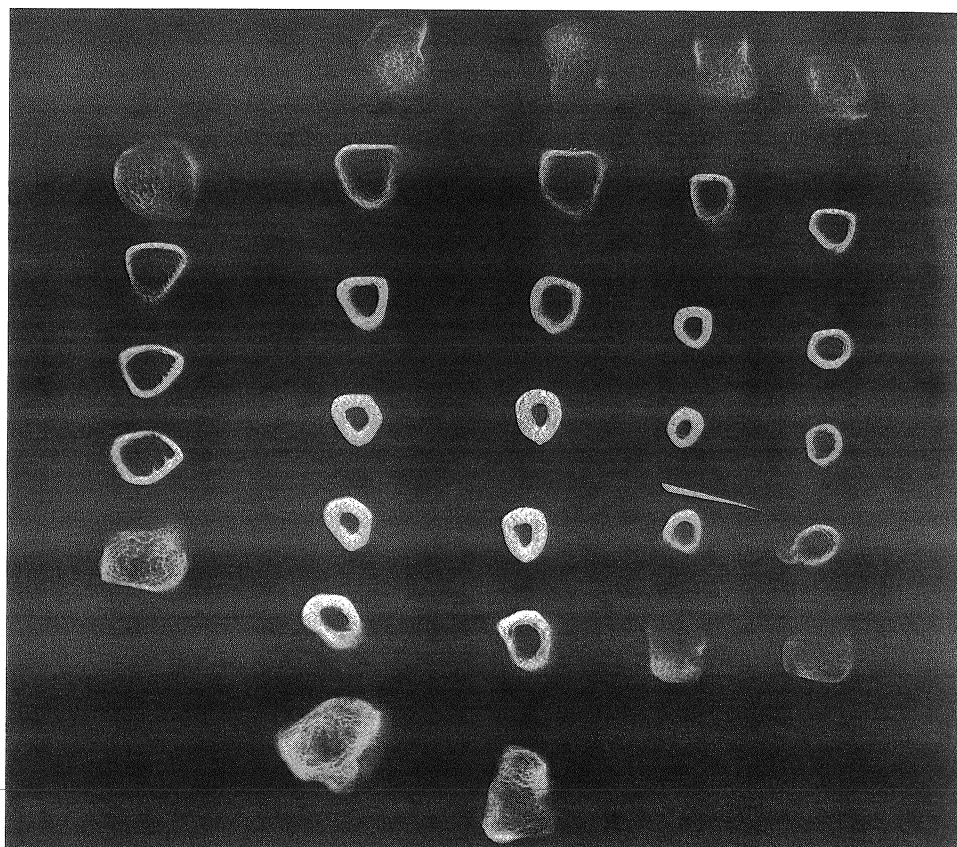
Radiographs of transverse sections, 10 mm in length, of each of the five metacarpal bones in sequential, longitudinal rows. Thumb metacarpal sections are on the left. The object-source distance is 14 inches. A, The right hand of a 42-year-old man.
